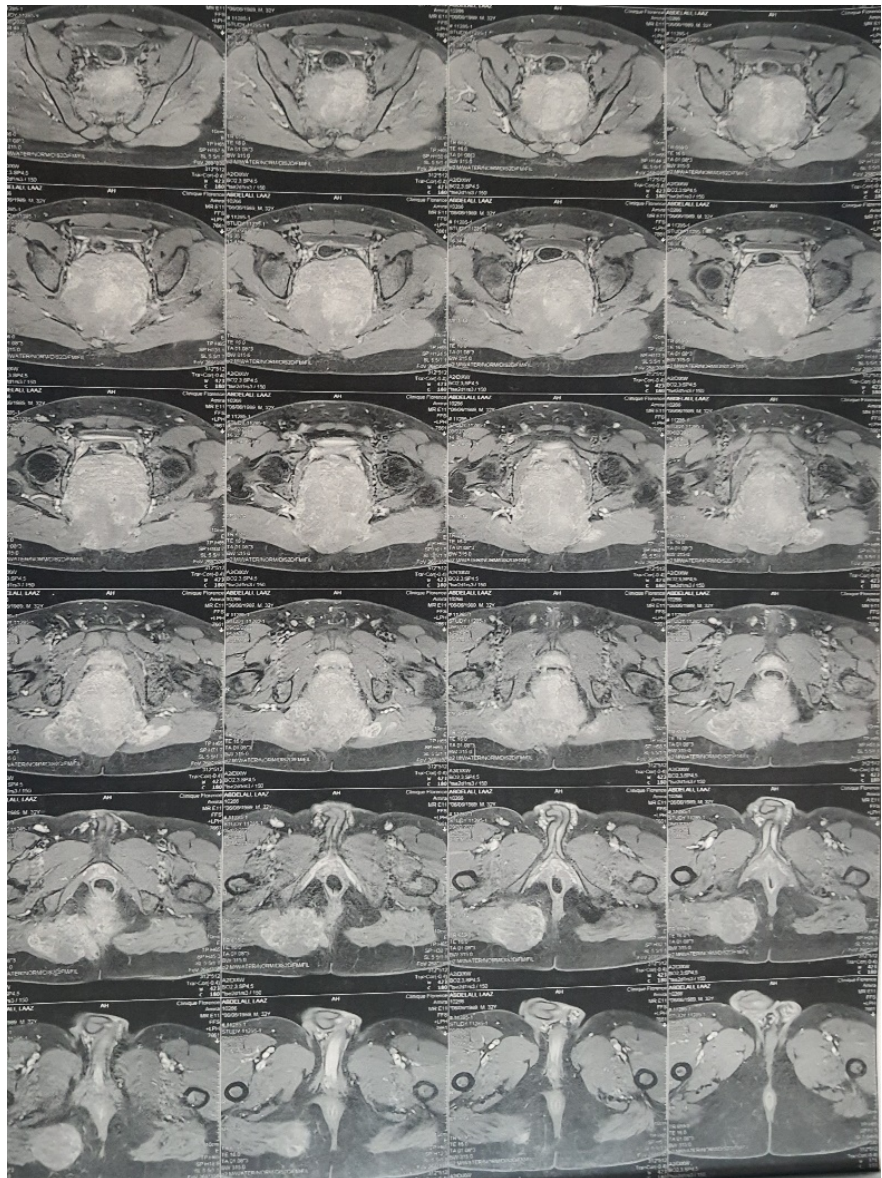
MRI images of our patient's tumour process.
